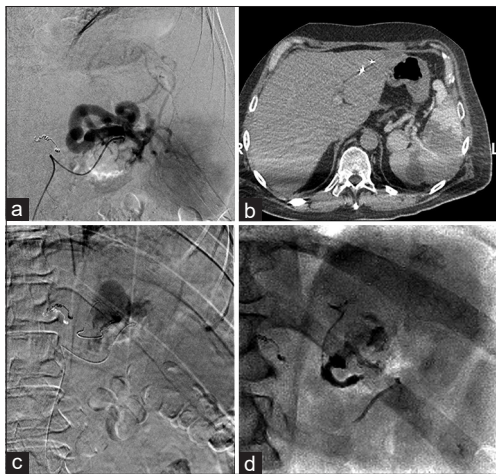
A 52-year-old male with a history of granulomatosis with polyangiitis and left nephrectomy 3 months earlier presenting for management of visceral pseudoaneurysms (PSAs). (a) Digital subtraction splenic angiogram did not show a clear origin of the pseudoaneurysm feeding vessel. (b) Intraprocedural computed tomography during contrast injection into the proximal splenic artery showed persistent flow within splenic PSA. (c) Digital subtraction angiogram after selecting a small inflow vessel arising off the proximal splenic artery showed a large PSA with outflow vessels through short gastric arteries. (d) PSA was successfully embolized using TRUFILL liquid embolic.
